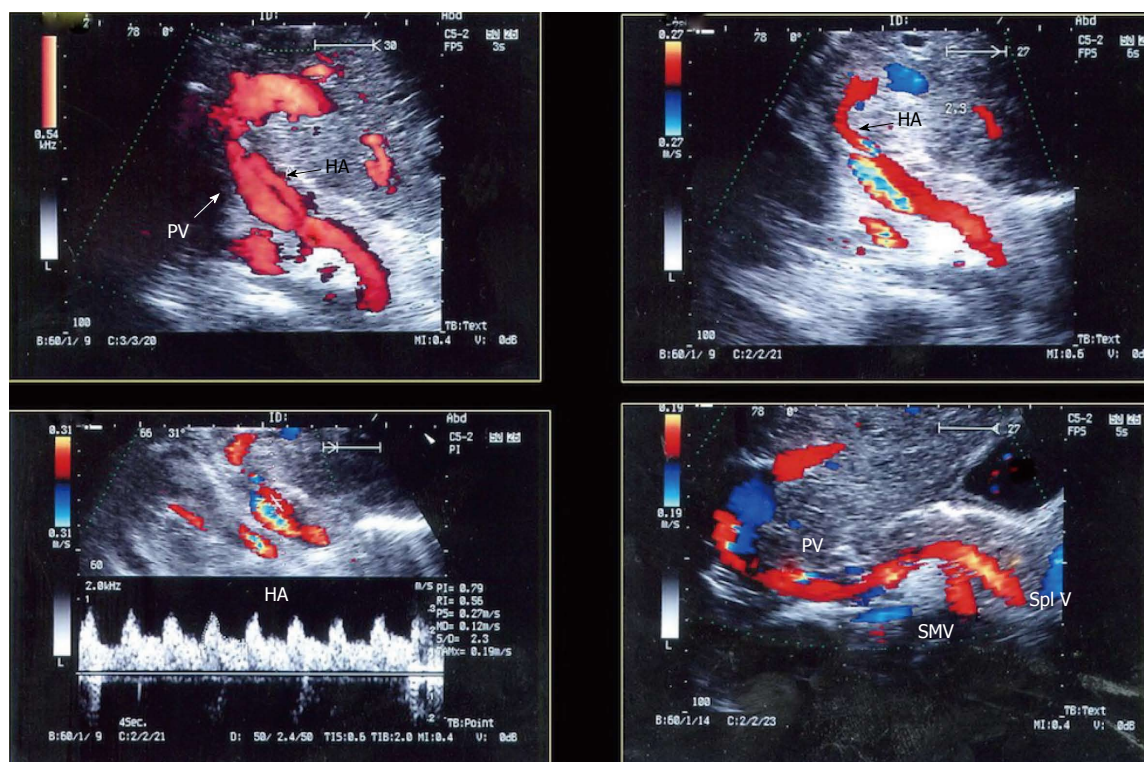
Intra-operative ultrasound evaluation of the portal vein and hepatic artery in left lobe transplants. Color Doppler images showing the PV and HA anastomoses. Note the C-shaped entry of the vessels at the graft hilum. PV: Portal vein; HA: Hepatic artery.
